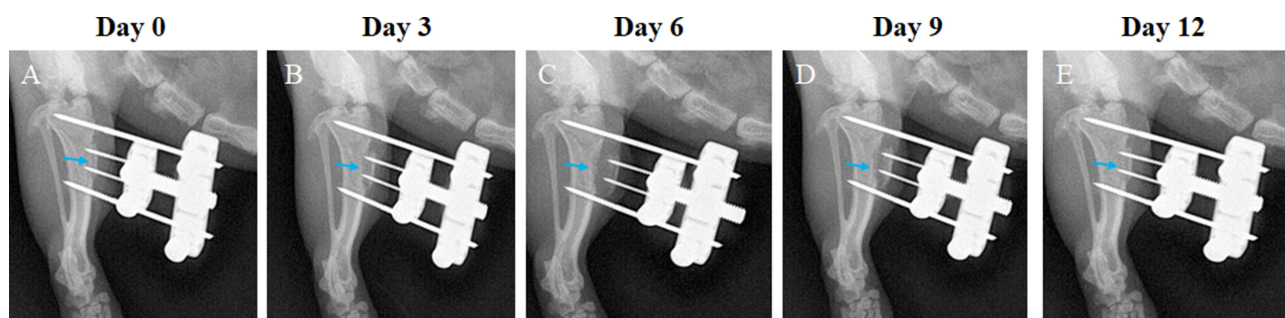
These postoperative radiographs show a tibia that underwent TTT. (A) The corticotomy and external fixator sites (arrow) were confirmed on radiographs immediately after surgery. (B) After 3 days of medial transport, the displacement of the corticotomized fragment was evident. (C) At day 6, the corticotomized fragment reached its maximum displacement. (D and E) This was followed by 6 days of lateral distraction, at the end of which (day 12) the corticotomized fragment returned to its original position and the external fixator was removed.
